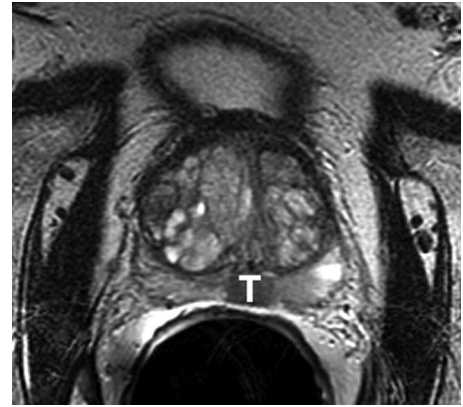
Biopsy-proved Gleason grade 8 adenocarcinoma in a 74-year-old man with a PSA level of 20.2 ng/mL. T2-weighted axial MR image shows a midline low-signal-intensity lesion in the peripheral zone with focal smooth bulging of the capsule. The patient was treated with intensity-modulated radiation therapy. The MR imaging findings, in particular the close spatial relationship between the tumor (*T*) and rectal wall, were helpful for designing the radiation treatment plan.
